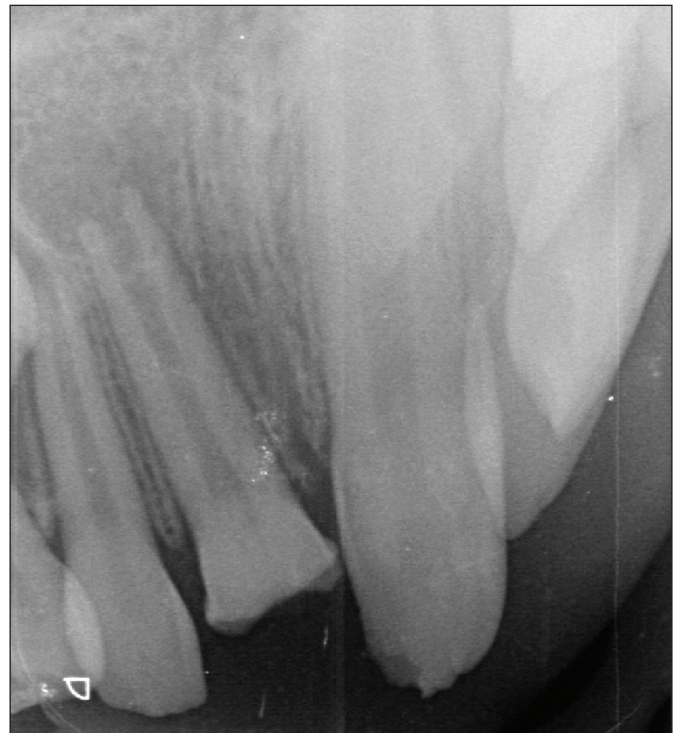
The first orthopantomogram of the patient.
